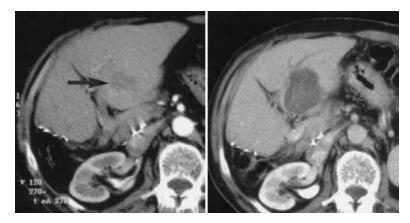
A 54-year-old man with colon cancer. A CT scan was obtained 3 months after right hepatectomy (left) shows hepatic 3-cm-diameter metastasis (arrow). A CT scan obtained at the same level 2 months after radiofrequency ablation of tumor (right) shows hypodense "scar." The scarred area is completely covering the site of the metastasis. Reprinted from de Baere, *et al.*,161 with permission from the American Roentgen Ray Society.
